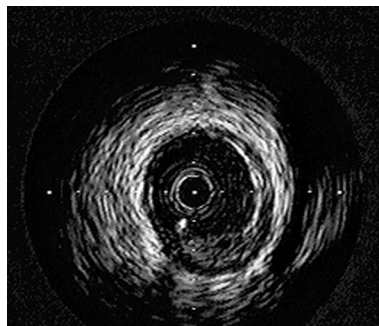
Slice obtained by intravascular ultrasound
